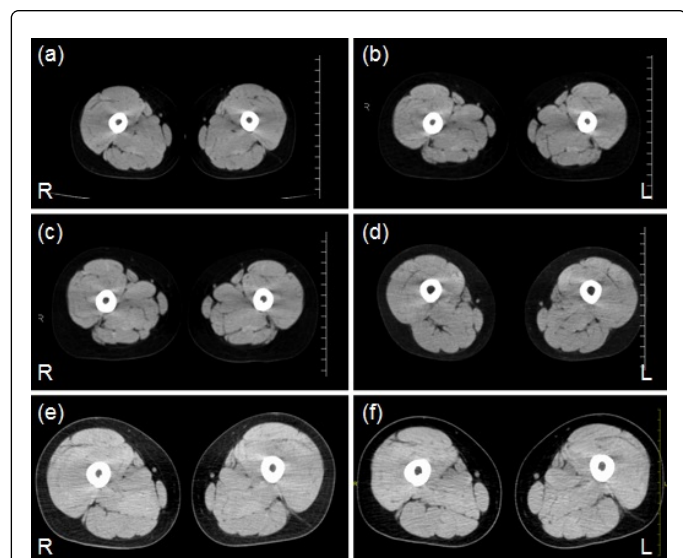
(a) Serial computed tomography scans of the thigh muscles before initiation of enzyme replacement therapy; (b) and after therapy, 1 year 4 months; (c) 2 years 5 months; (d) 4 years 9 months; (e) 6 years 3 months; (f) and 7 years 8 months.
